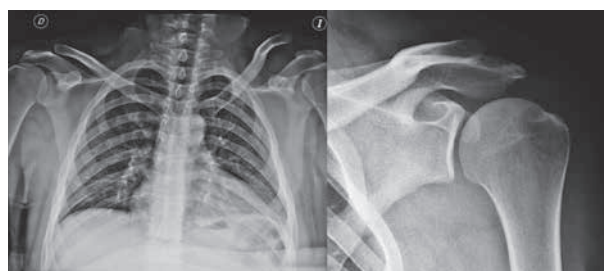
Radiographs with the initial lesion and final result 2 years follow-up.
